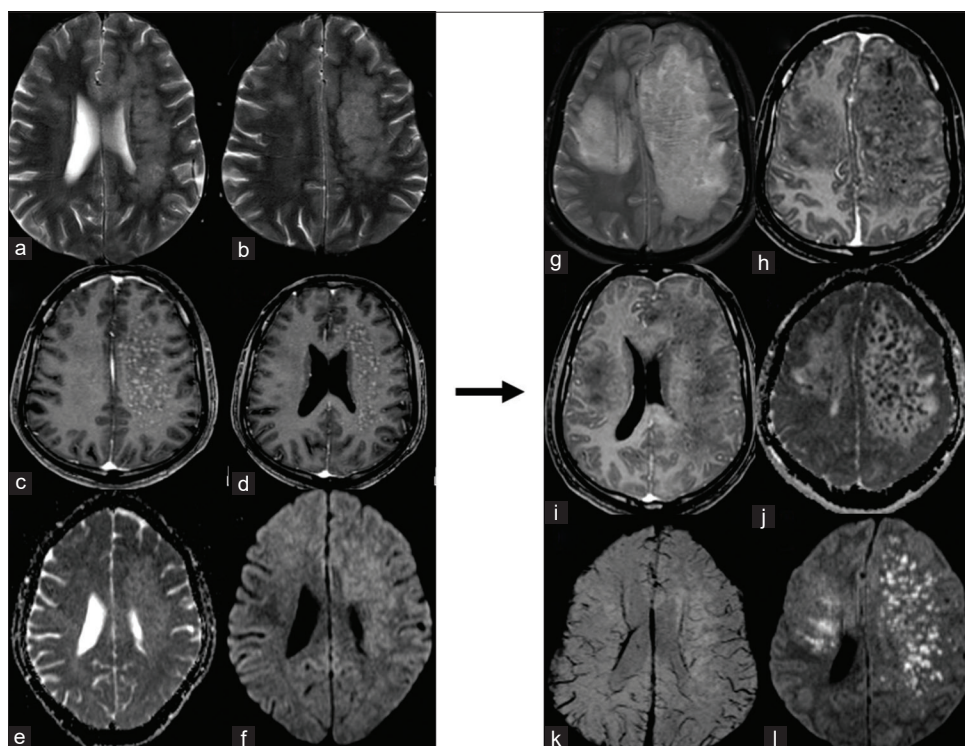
A 40-year-old male with aspergillosis infection. Baseline (a-f) and post-steroid therapy MRI brain (g-l) show T2W intermediate signal area with hypointense nodular areas within, in the left cerebral white matter (a and b). Numerous micronodular enhancing foci (c and d) and areas of mildly low ADC values (e and f) were also noted. Following steroid administration, the disease progressed with a more aggressive appearance spreading to contralateral parenchyma (g-i). Multiple new areas of low ADC also appeared (j and l). Fungal elements were found in the blood culture. ADC: Apparent diffusion coefficient
